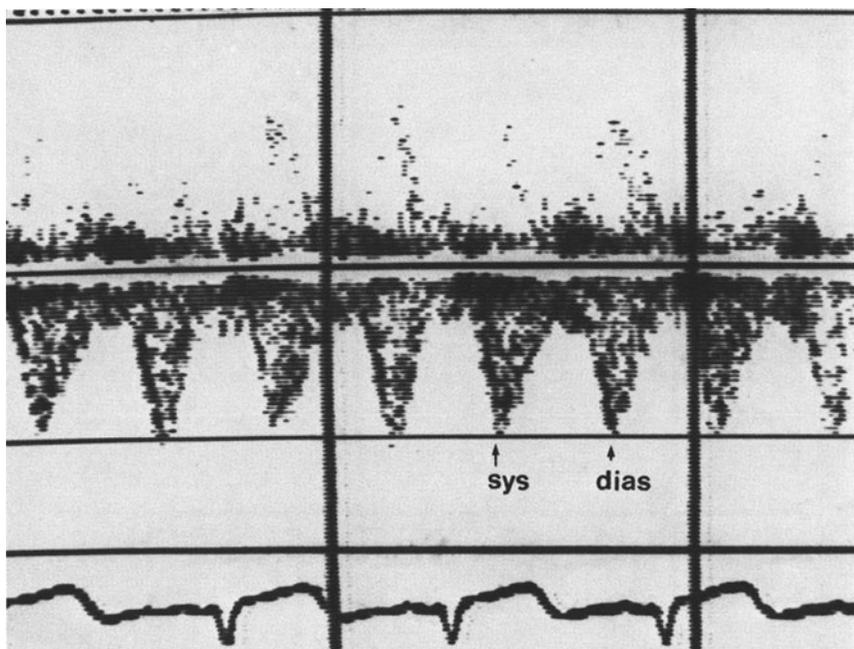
Doppler trace from a postoperative Senning patient demonstrating equal systolic and diastolic flow in the pulmonary veins.
